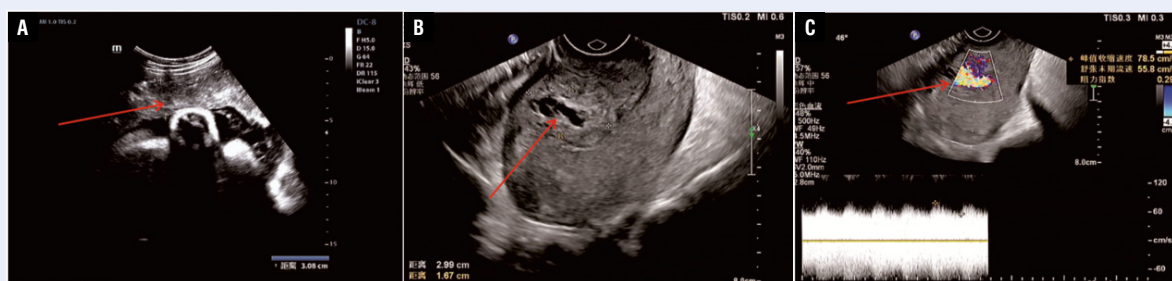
B-ultrasonography revealed the placenta lodged of the uterus (red arrow); B. Transvaginal sonography image of the uterus a low-echoic cystic lesions (red arrow); C. Color-flow Doppler revealed a mosaic pattern of blood flow (red arrow)
